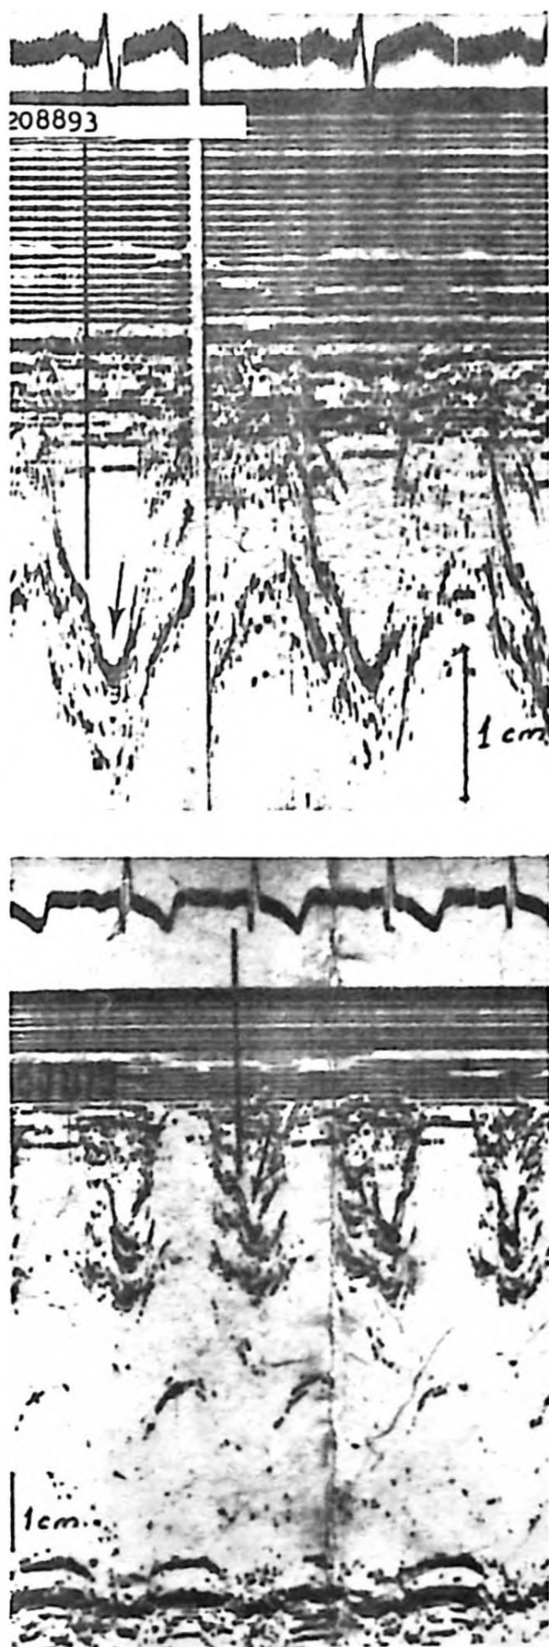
The echocardiograms of two cases with moderate (a) and severe (b) pulmonary stenosis are seen. The "a" wave depths in these cases are greater than normal.
